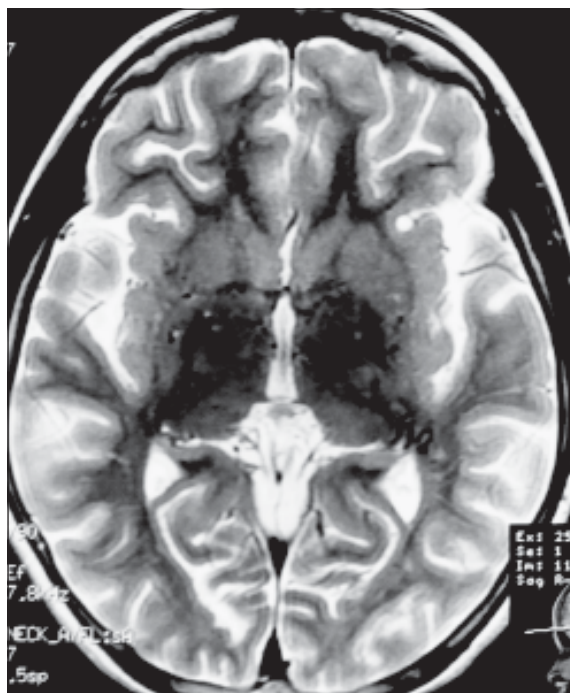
MRI in T2WI (Axial view) shows multiple flow voids in the area of circle of Willis and in the basal ganglia.
